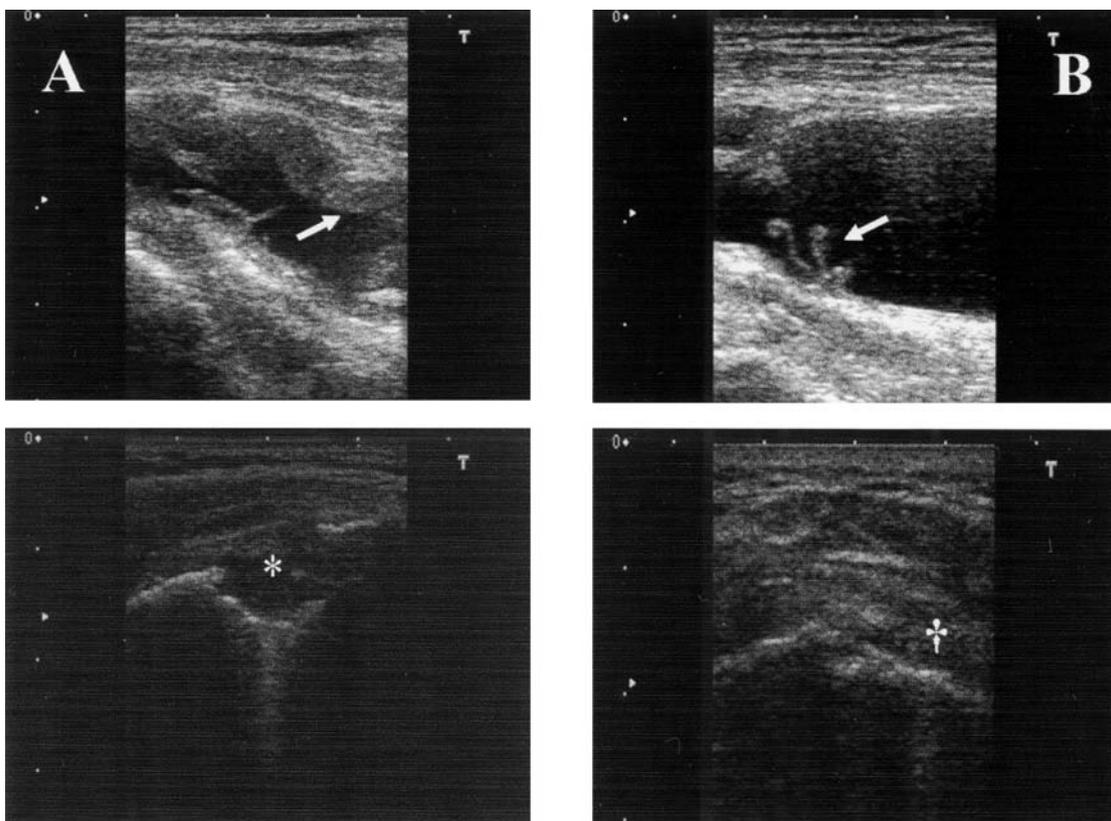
Ultrasound images. A. Patient 2 (longlasting disease): large glenohumeral joint effusion, synovial hypertrophy (arrow), complete rotator cuff tear (\*). B. Patient 8 (early disease): large glenohumeral joint effusion, synovial hypertrophy (arrow), partial rotator cuff tear (†).
